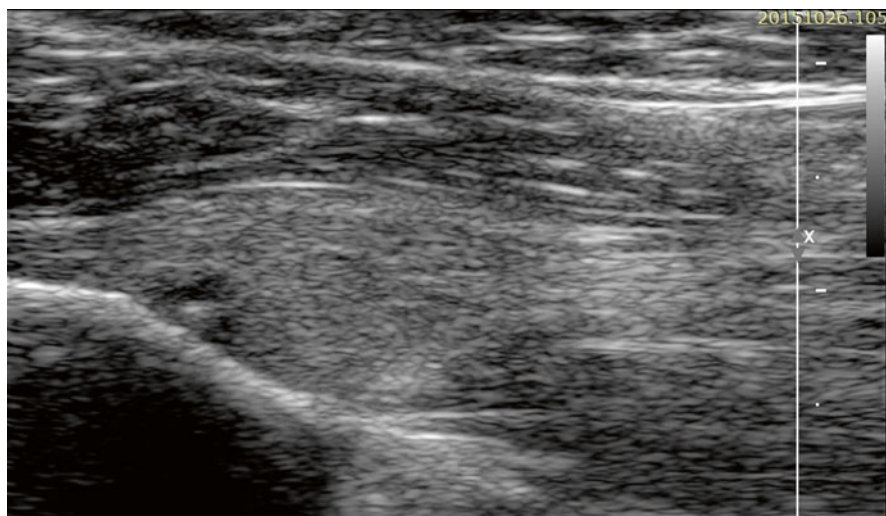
Longitudinal ultrasound scan in rectus femoris tendinopathy; the tendon is thicker with changes in its structure
